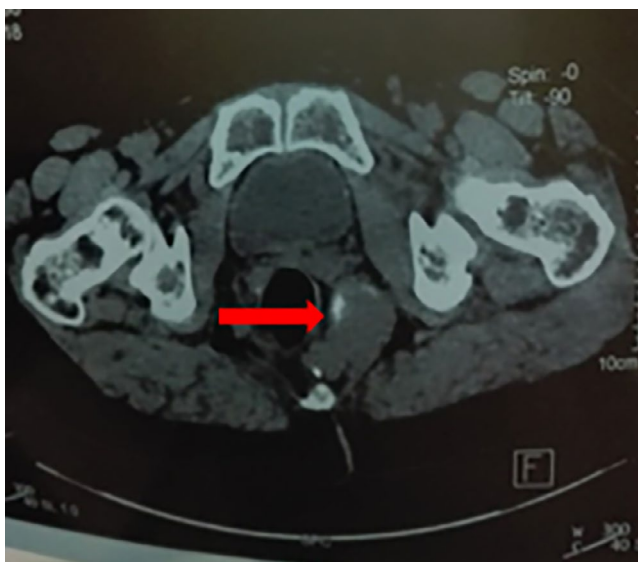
Axial sections of the abdominopelvic CT scan showing the tailgut cyst with wall calcification
